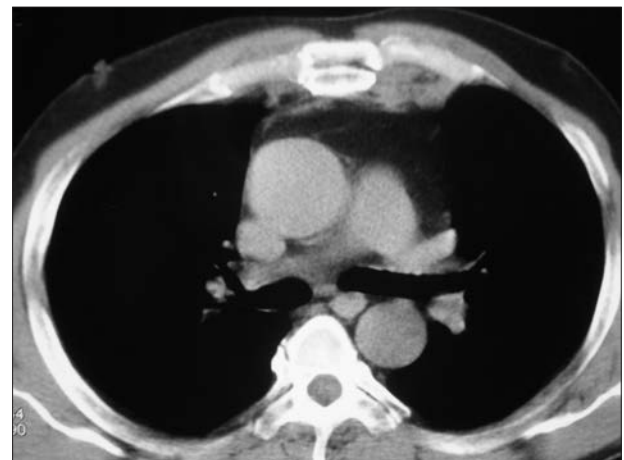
Overlapping fractured sides on computed tomography
